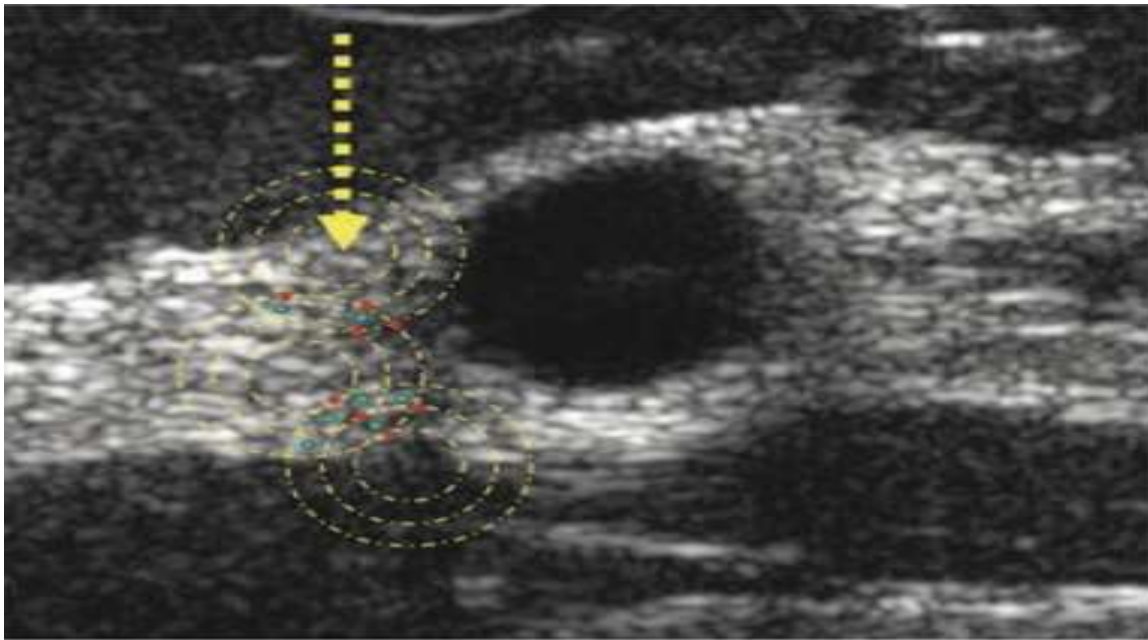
Ultrasound speckle. Close examination of an ultrasound image of a breast containing a small cyst reveals that it is composed of several areas of varying intensity (a spot). The spot results from the constructive (red) and destructive (green) interaction of sound fields (yellow rings) generated by the scattering of ultrasound waves from devices. Detection of small tissues. This interference pattern gives ultrasound images their characteristic grainy appearance and may reduce the contrast of the ultrasound spot that is the basis of the tissue seen in ultrasound images of solid tissues.[22]
